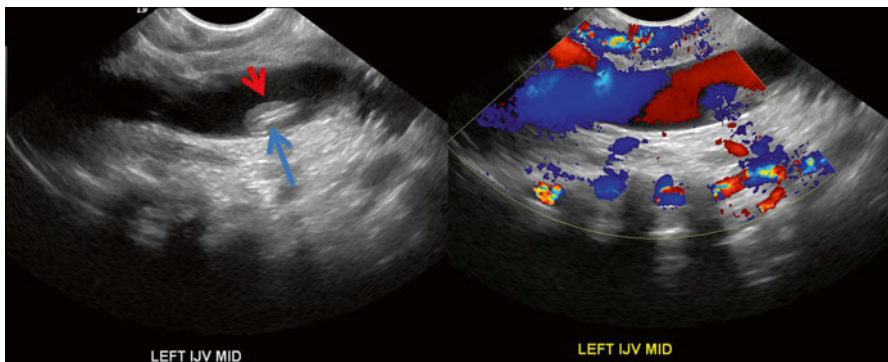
Gray scale (*left panel*) and color Doppler ultrasound image (*right panel*) of the left neck of an ICU patient with a central venous catheter in place demonstrate an eccentrically located intraluminal echogenic focus within the left internal jugular vein at the mid-portion, which represents a thrombus (*red arrow*). Note the presence of the linear intraluminal echogenic focus (*blue arrow*) associated with the thrombus, which represents the patient's central line. The color Doppler image demonstrates turbulent blood flow in the area of the thrombus
